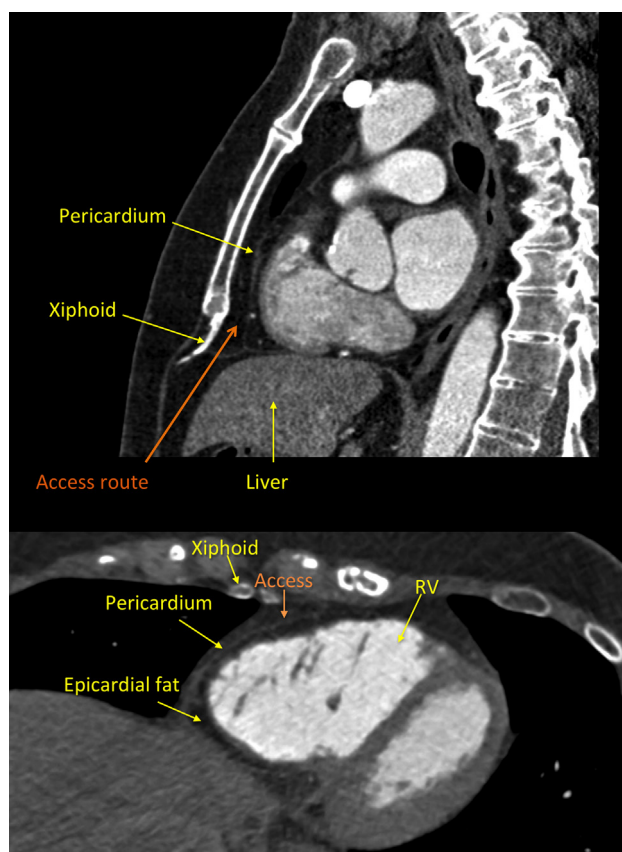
Magnetic resonance imaging views for pericardial access. Top panel: Sagittal view; bottom panel: transverse view). The needle traverses the superficial fascia, anterior rectus sheath, rectus abdominis muscle, and posterior rectus sheath and then over the dome of the diaphragm before reaching the fibrous and parietal serous layers of the pericardium. RV = right ventricle.
